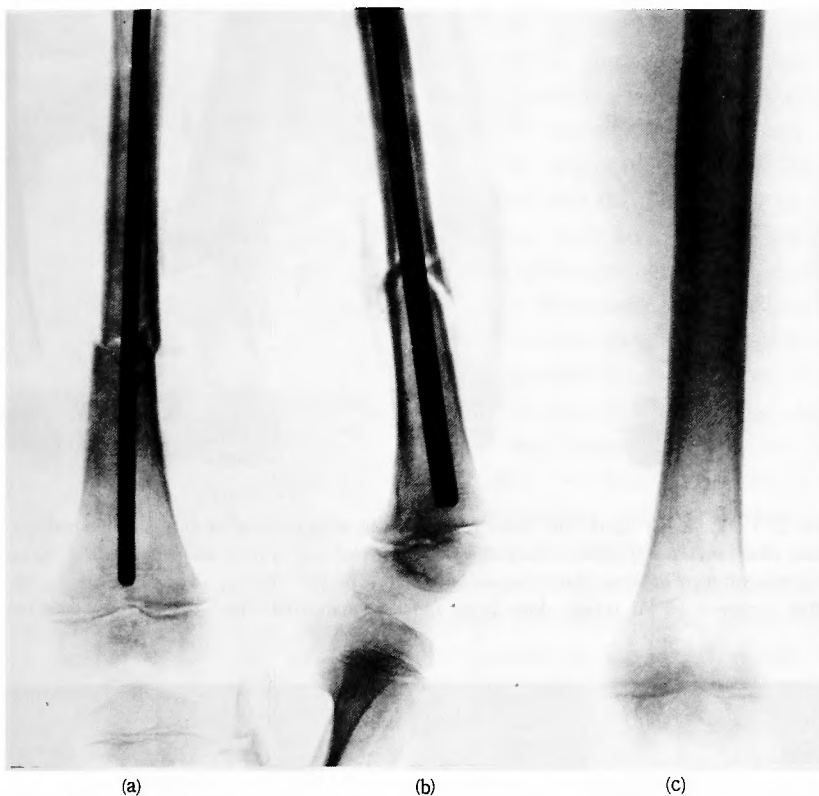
Case 9. K. T., a boy aged six years. (a), (b) The intramedullary nail of clover-shape was used for the osteosynthesis. (c) The roentgenogram was taken at review one year six months after surgery.
